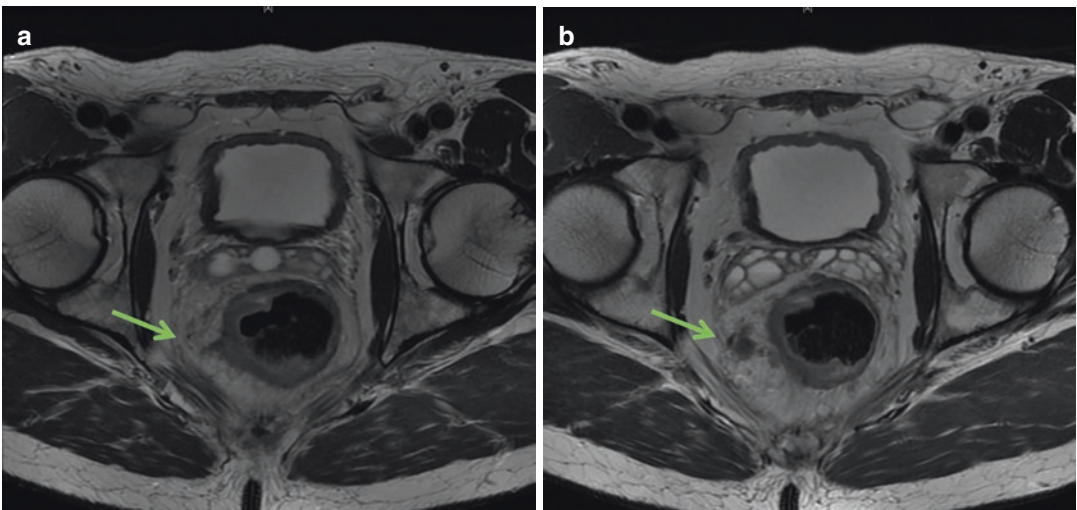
Axial views of an MRI of the rectum with a rectal tumor penetrating into the perirectal fat (a) and involving the mesorectal nodes (b)
